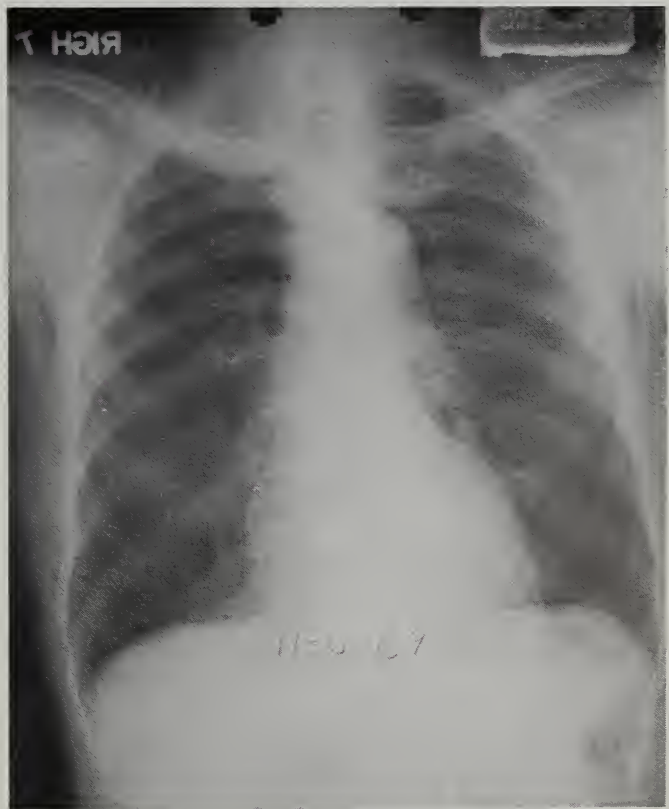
Chest x-ray showing right apical density.
